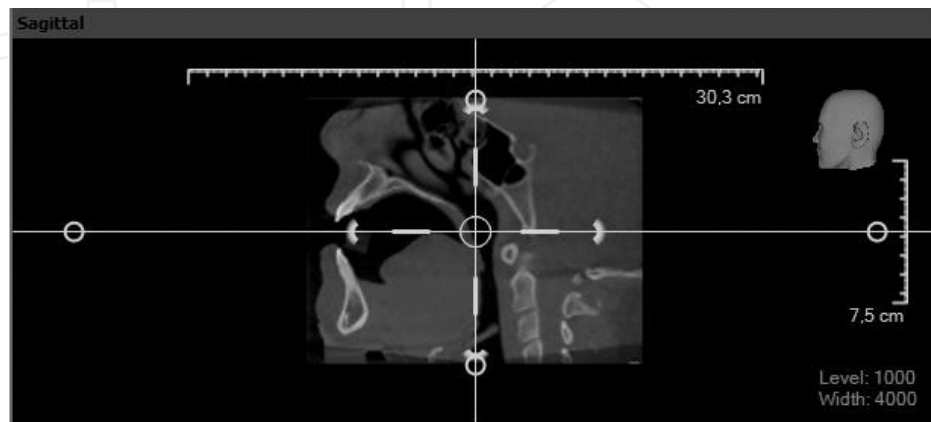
An example of a sagittal slice of CBCT image
